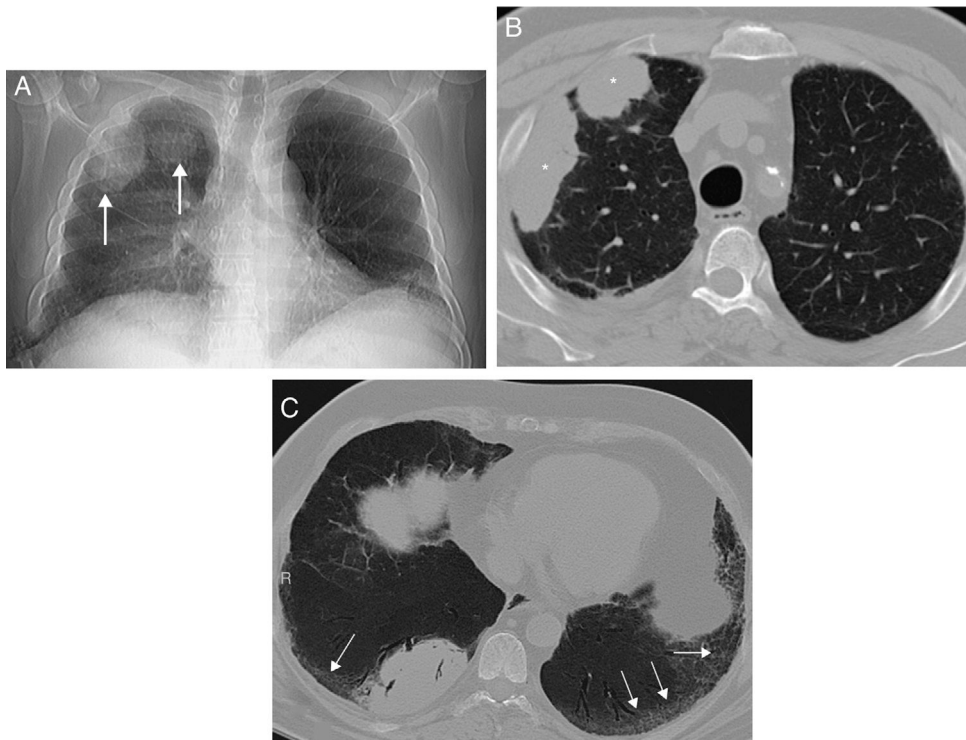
(A) Posteroanterior X-ray of the chest in which several nodular opacities are observed in the right lung (arrow). Note the presence of a subtle bibasal enlargement of the lung interstitium. (B) Axial image of chest CT which confirms the presence of right lung masses (asterisks). (C) Axial image of chest CT (minimum intensity projection) in which a bibasal lung interstitium reticulation (arrows) may be observed in relation to the patient's interstitial lung disease. Note the presence of small traction bronchiectasis.
